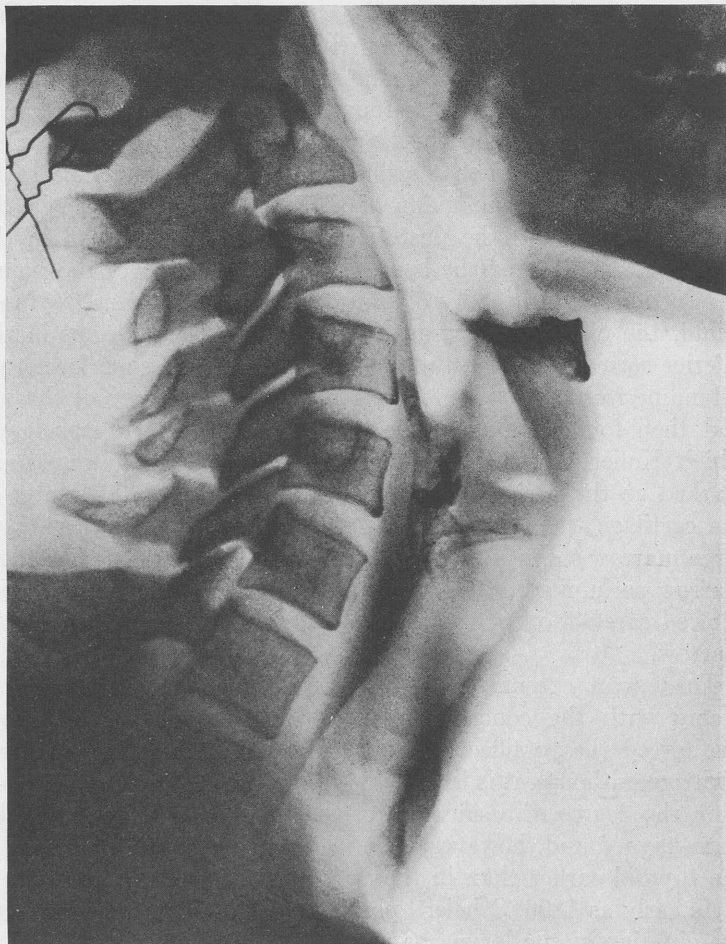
A roentgenogram of the larynx of a woman, aged thirty-three years, showing a dense ossification of the arytenoids and partial ossification of the superior and inferior cornua.
